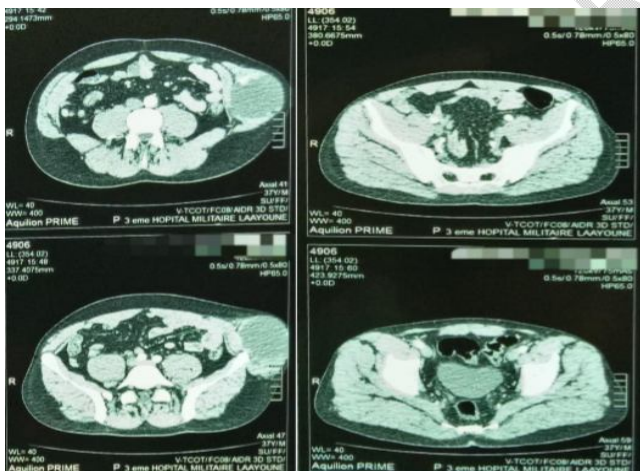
Axial CT section showing the mass
